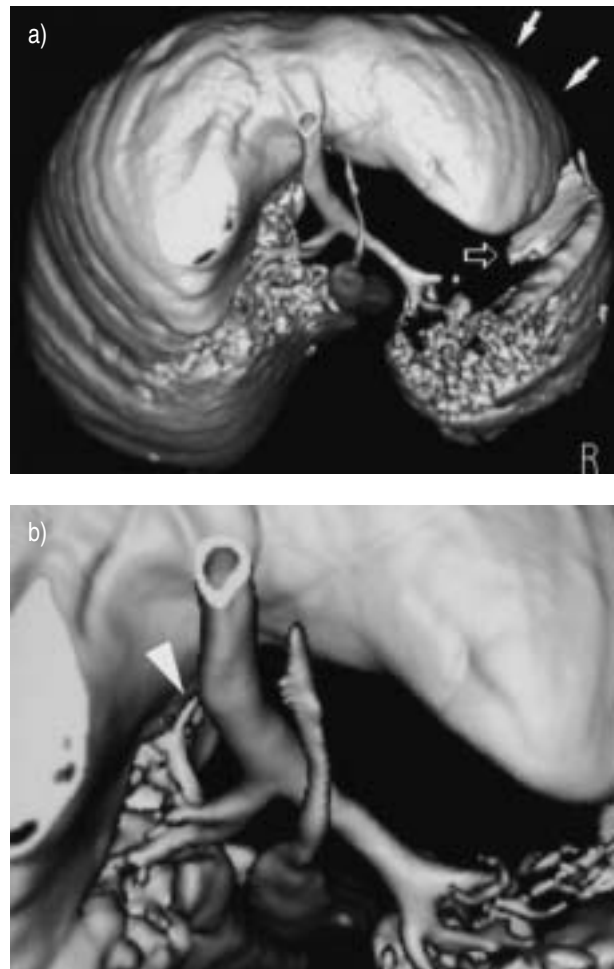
a) Thorax computed tomography scan with a three-dimensional model. b) Magnification. The lungs are seen from behind.
